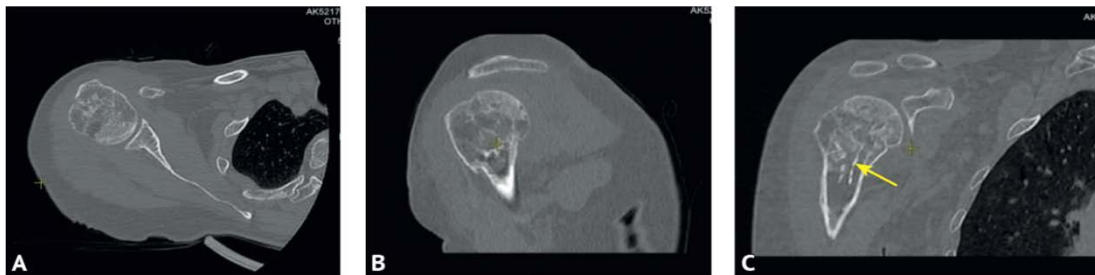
Multislice computed tomography of the right shoulder joint after plate removal. A — axial slice; B — sagittal reformation; C — front plane reformation (the arrow indicates the residue cortical graft layer)
